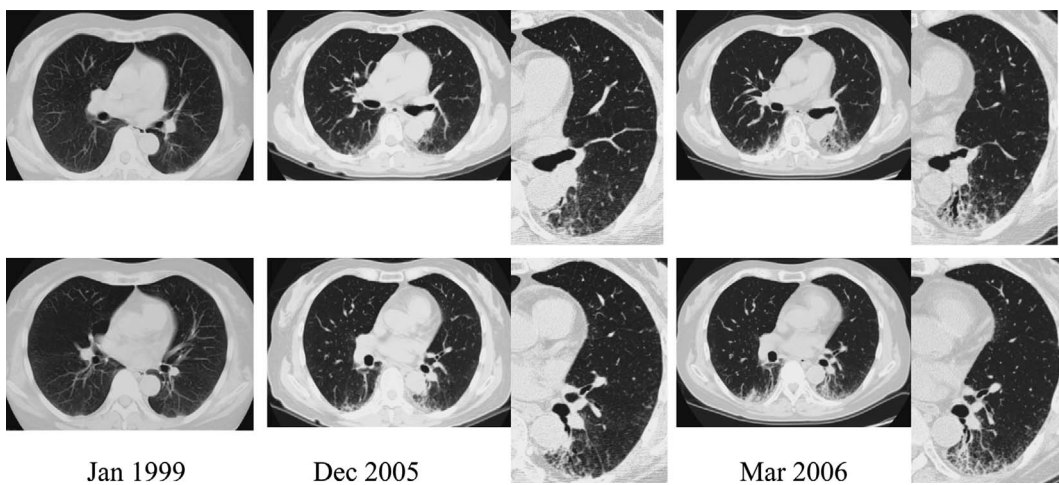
Chest CT scan obtained over the clinical course. Some reticular shadows were seen in the posterior the lower lobes in 1999. The lower lobes were smaller, and traction bronchiectasis and linear opacities were seen in December 2005. In March 2006, fresh ground glass opacities and reticular shadows were seen.
